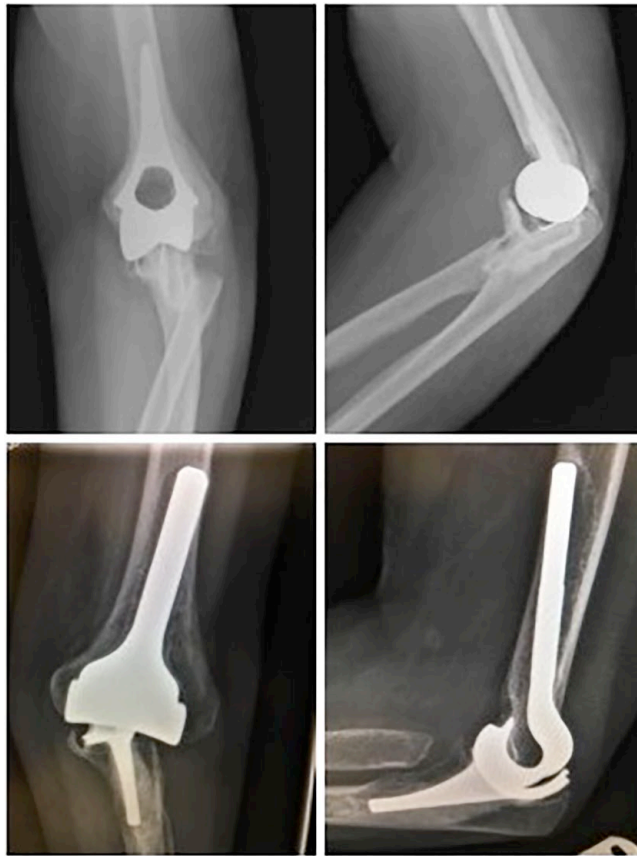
Radiographs presenting two commonly used unlinked prostheses in the past: Souter-Strathclyde (top) and Kudo (bottom).
